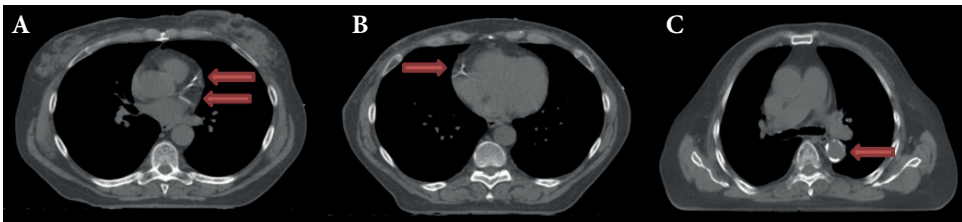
Radiotherapy planning CT scans with calcifications (shown white and highlighted with a red arrow) in the left anterior descending artery (A, highest red arrow), left circumflex artery (A, lowest red arrow), right coronary artery (B), and thoracic aorta (C).
